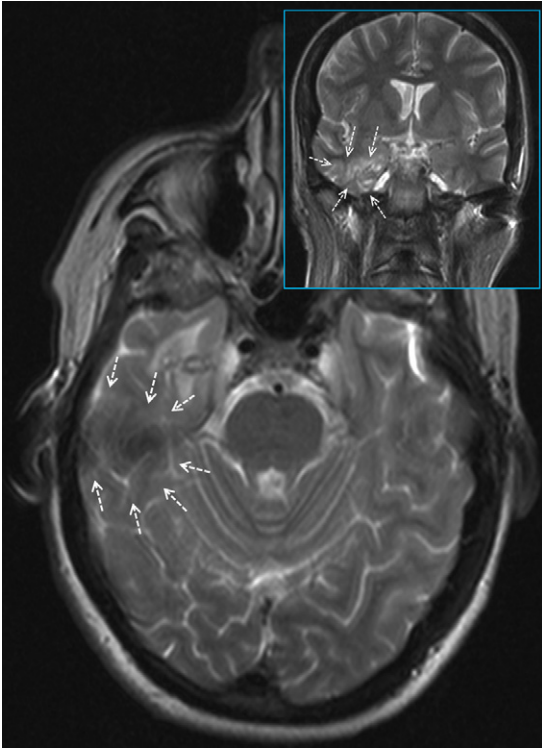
Axial magnetic resonance image (MRI) one week after arthroscopy showing a signal change in the anterior aspect of the right temporal lobe. Inset: coronal MRI showing increased contrast just superior to Meckel's cave at the cavernous sinus.
